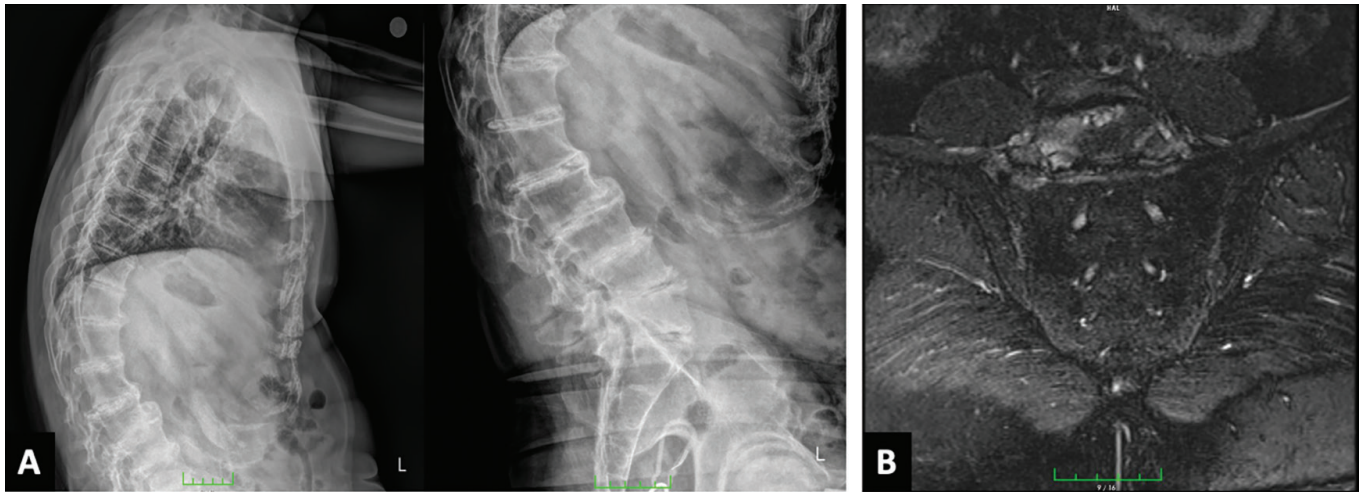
Radiographic and MRI assessment of the spine and sacroiliac joints. (A) Spinal radiographs demonstrating multilevel intervertebral disc space narrowing with characteristic “wafer-like” discal calcifications and subchondral sclerosis. (B) Contrast-enhanced fat-saturated T1-weighted MRI of the sacroiliac joints showing normal joint spaces and no evidence of active sacroiliitis (no pathological contrast enhancement or bone marrow edema)
